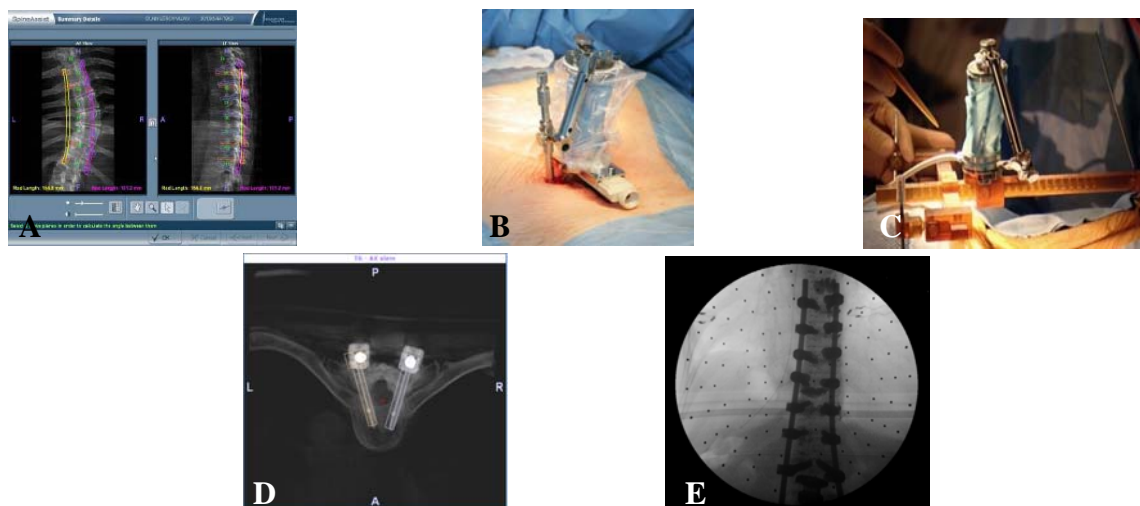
(A) Planning summary of a multi level thoracic fixation case. (B) The Multi-Level Bridge anchored to the patient's bony anatomy via Clamp. (C) The Hover-T frame anchored to the patient's bony anatomy via three small incisions. (D) Post-op CT analysis showing perfect alignment of plan to execution in a percutaneous case. (E) Fluoroscopic images of multi level thoracic fixation case.
